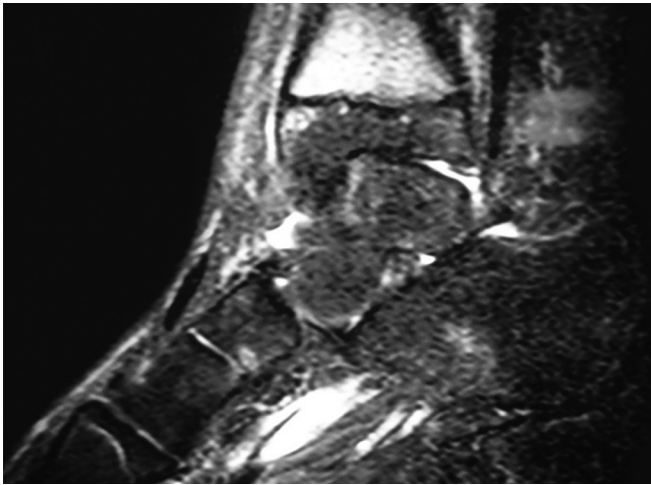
MRI of the ankle showing osteolytic lesion in tibial metaphysis (chronic recurrent multifocal arthritis)
